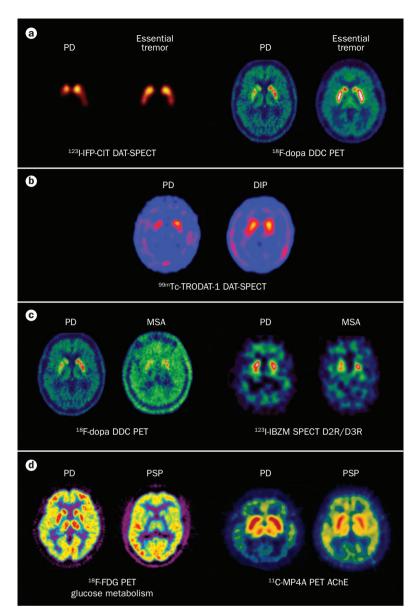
Imaging for differential diagnosis. a | PD and essential tremor can be differentiated by measurement of DAT activity in the striatum via SPECT, or DDC activity via PET. b | DAT-SPECT scans of the striatum can also be used to differentiate PD from DIP. c | PET scans targeting DDC activity and D2R/D3R availability can help differentiate between PD and MSA.  $\mathbf{d}$  | Glucose metabolism in the striatum and thalamus, and thalamic AChE activity, can reveal differences between PD and PSP. Abbreviations: AchE, acetylcholinesterase; D2R/D3R, dopamine D2 and D3 receptors; DIP, drug-induced parkinsonism; MSA, multiple system atrophy; PD, Parkinson disease; PSP, progressive supranuclear palsy.
